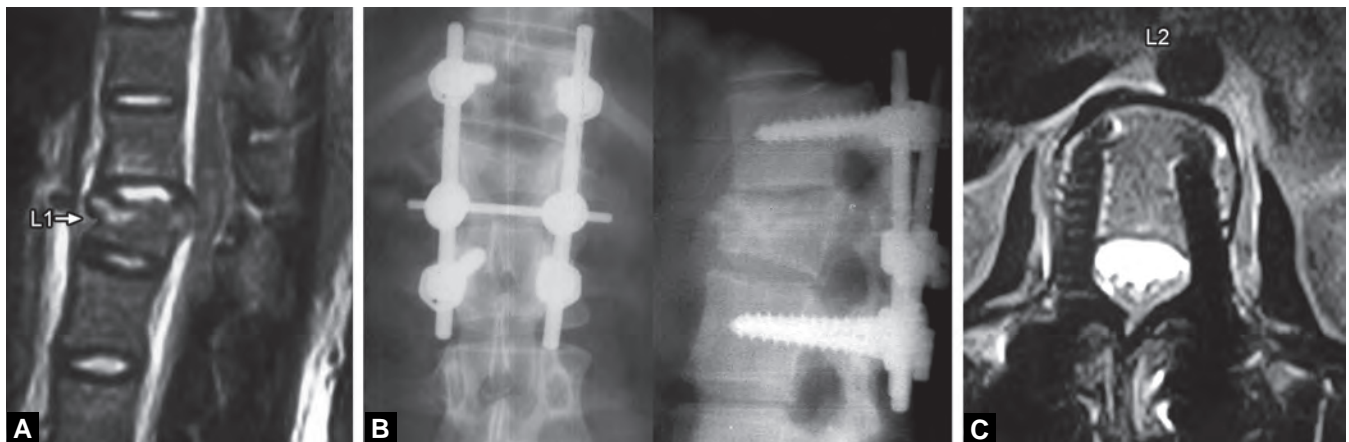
Sagittal and axial CT of L1 unstable burst fracture with retropulsed fragment (left), treated by short segment pedicle screw (Moss Miami type) system. Note the correction of kyphosis in the post-operative radiographs (right)
